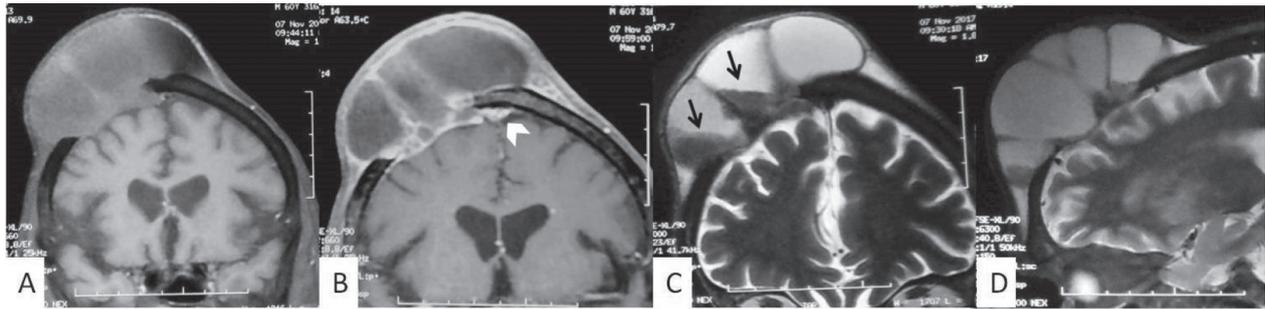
Magnetic resonance imaging: T1-weighted image (A), coronal T1-weighted image with gadolinium (B), coronal T2-weighted image (C), and sagittal T2-weighted image (D), showing a multilobulated cystic mass with liquid-liquid levels (arrow) responsible for bone lysis, invading the dura mater and coming into contact with the superior sagittal sinus, which remains permeable (arrowhead).
